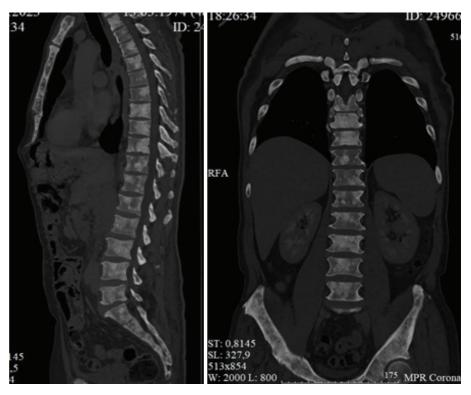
CT of bones. Multiple foci of osteosclerosis in the bones
